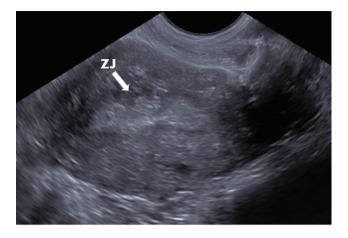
Longitudinal view of the uterus obtained by ultrasound in B-mode. The irregular and discontinuous junctional zone (JZ) in the anterior wall of the endometrium (white arrow).
